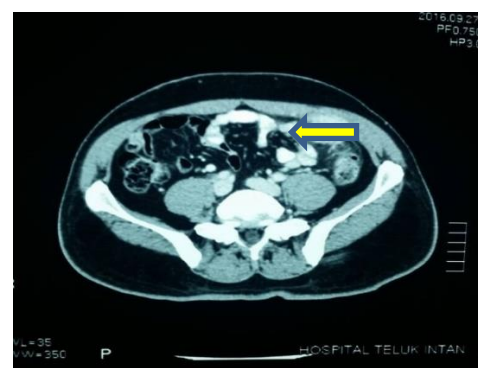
CT Scan showing the anterior abdominal tumour (yellow arrow).
